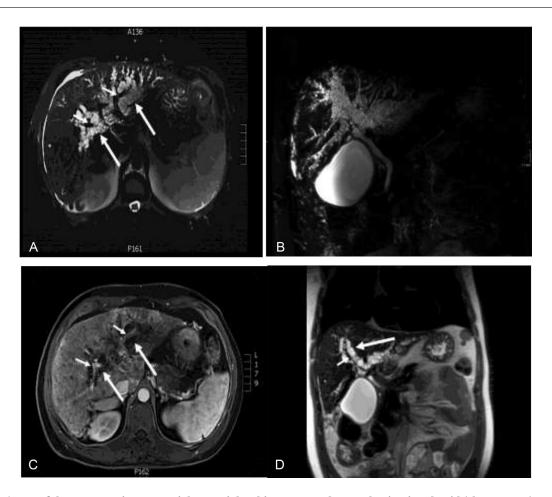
(A-D) MRI of the same patient. A. Axial T2 weighted image reveals portal vein signal void (short arrow) and peribiliary cysts circumferential to portal vein tract (long arrow). B. Coronal MIP MRCP image shows clustered cysts along the intrahepatic biliary tree. C. Postcontrast T1 fat saturated image confirms the portal vein enhancement (short arrows), and peribiliary cysts appear hypointense around the portal vein. D. Same findings are also demonstrated on coronal T2 weighted image.
